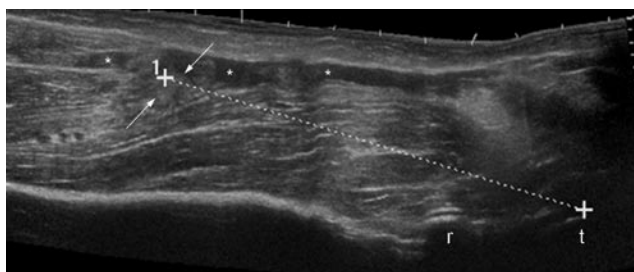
Longitudinal panoramic ultrasound image of the biceps tendon shows the torn biceps tendon (arrows) displaced from the radial tuberosity (t). The dotted line between cursors spans the distance measured between the radial tuberosity and the distal end of the retracted biceps tendon. Hematoma (*), radial head (r).
